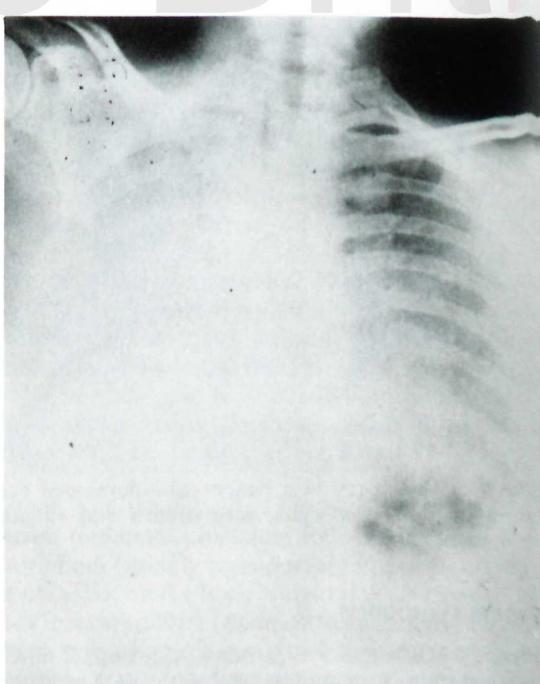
Chest X-ray showing total opacification of the right lung field and partial opacification of the left field
